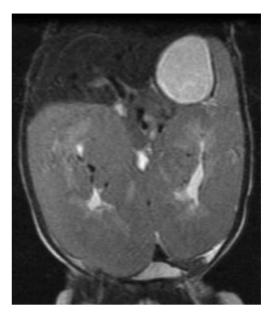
Diffuse nephroblastomatosis. Coronal T2-W MR image showing diffuse enlargement of both kidneys and diffuse thickening of renal cortex (courtesy Dr. A. Smets, AMC, Amsterdam, The Netherlands)
